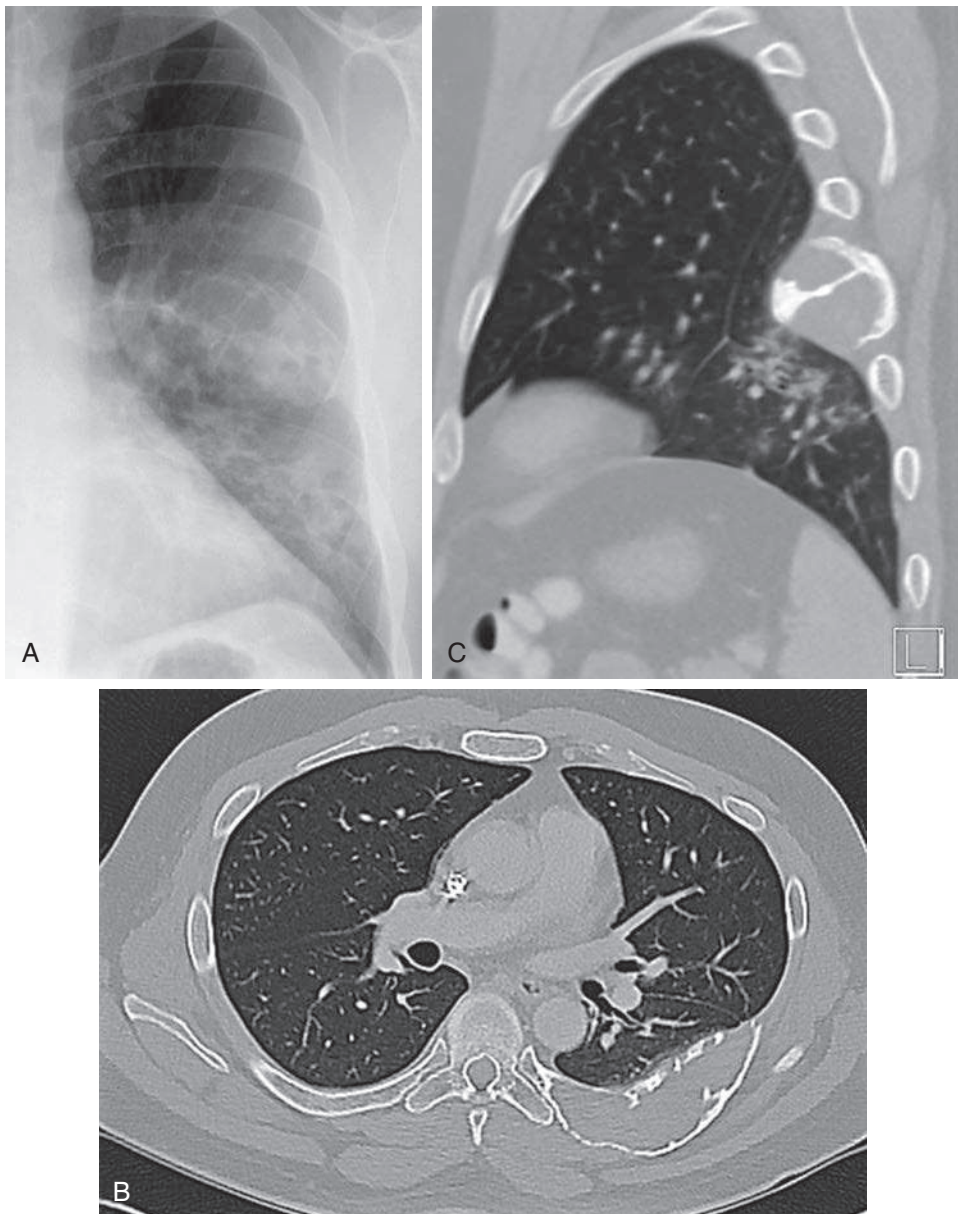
A, PA chest radiograph shows a large elongated mass with expansile destruction of a posterior rib. B, Axial computed tomography confirms the large mass with expanded rib cortex. C, Sagittal reconstruction shows destruction of the anterior rib cortex and a large soft-tissue mass with tapered superior and inferior borders. These findings could result from metastasis, but this is another case of multiple myeloma.
